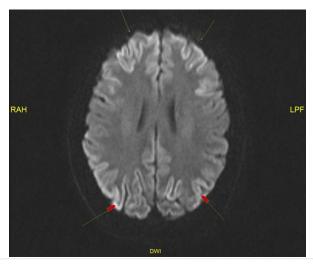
DWI image: Matched Gyral restricted diffusion with ADC.
